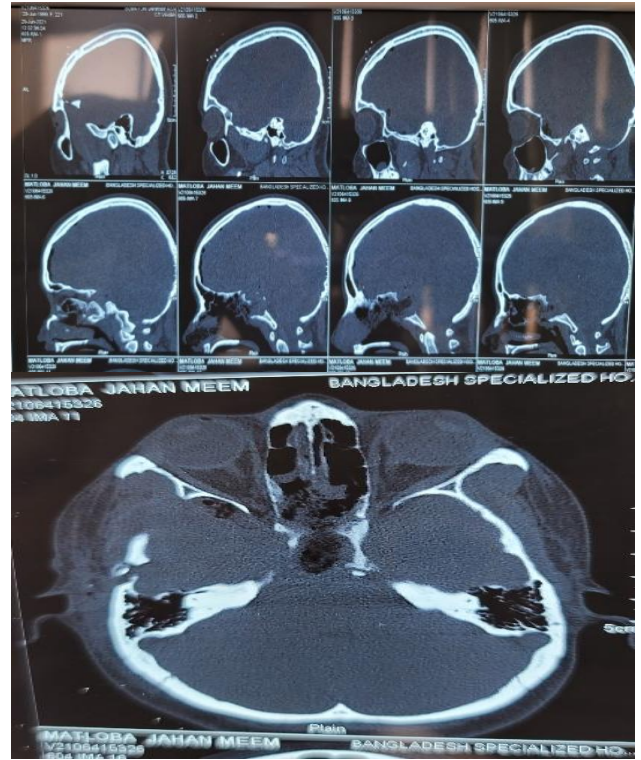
CT scan of base of skull, gross bony erosion was present in sphenoid bone.
